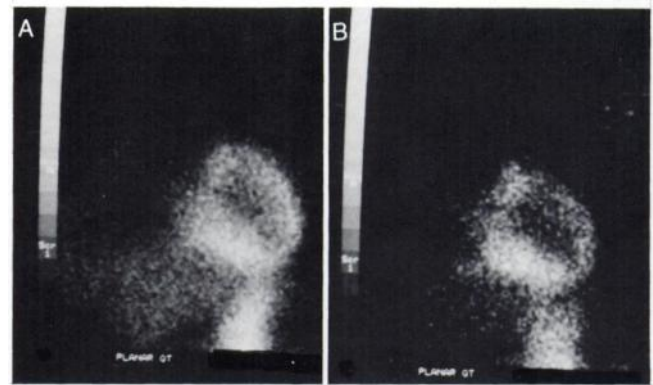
Thallium-201 myocardial scintigraphy. Rest (A) and redistribution (B) anterior projection. Normal ^{201}Tl uptake is observed in all myocardial segments on rest image, while on redistribution image the anterior segments show a lower than normal ^{201}Tl uptake (reverse redistribution pattern A).
